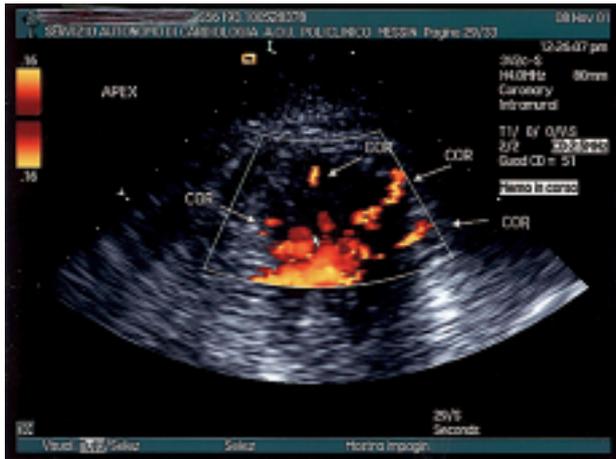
Apical 4-chamber view (left panel) in patient A (mid-apical hypertrophy). Four small intramyocardial coronary branches may be seen at power-Doppler echocardiography. The pulsed-wave Doppler velocity sampling refers to the largest branch (right panel). The diastolic velocity, from the epicardial to the endocardial edge, is > 100 cm/s, while the systolic flow appears to be reverted (arrows). Two-dimensional image settings: transducer frequency 4 MHz; depth 80 mm; power spectrum range 16 cm/s; gain 51 dB. COR = intramyocardial coronary branches; SYST = systolic flow velocity.
